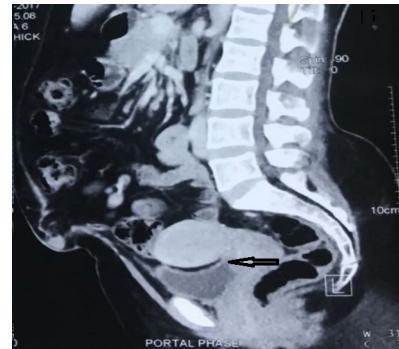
CT urography with contrast suggestive of vesicouterine fistula (black arrow).
